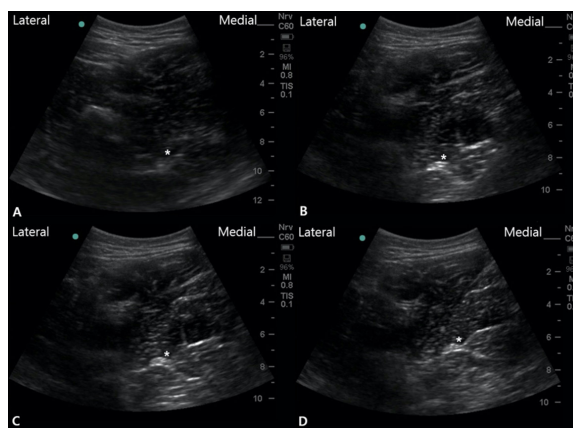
The ultrasound images of the sciatic nerve in 4 leg positions
